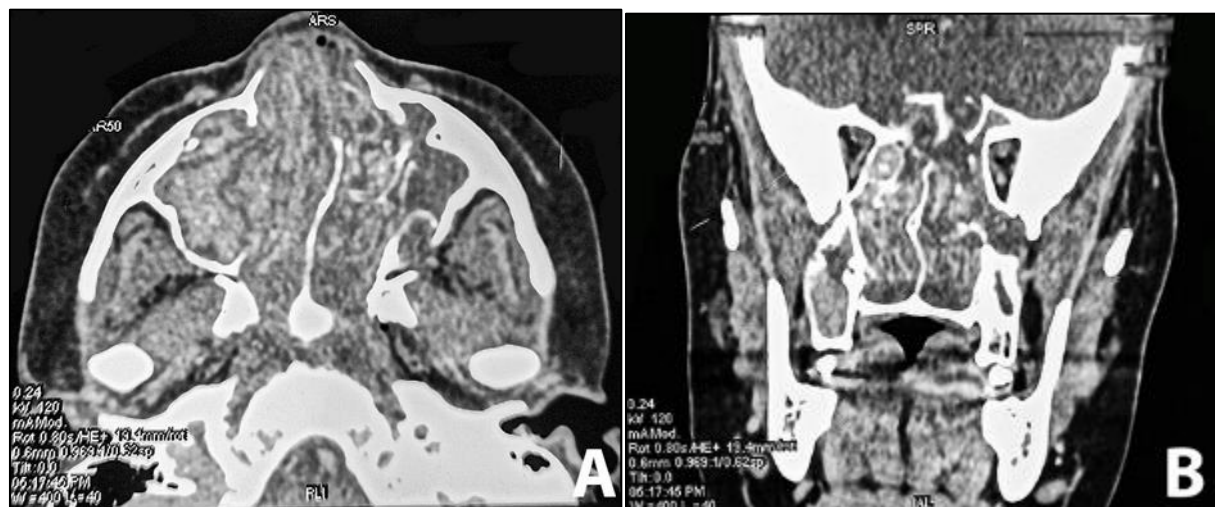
Facial CT scan with A: Axial Cuts showing the extent of the masses within the nasal cavity and sinuses. And B: Coronal Cuts highlighting the involvement of the maxillary, ethmoidal, and sphenoidal sinuses, as well as the bony remodeling and erosions
